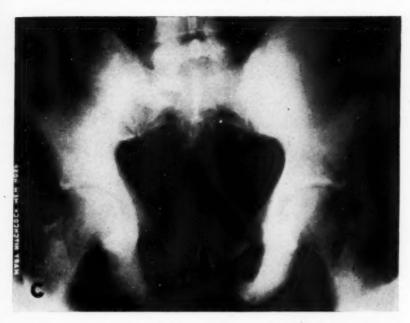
C. Roentgenogram of patient shown in Figs. 2A and 2B, five months after the metastatic lesions had apparently disappeared. There are now extensive diffuse metastases throughout the entire pelvis.
